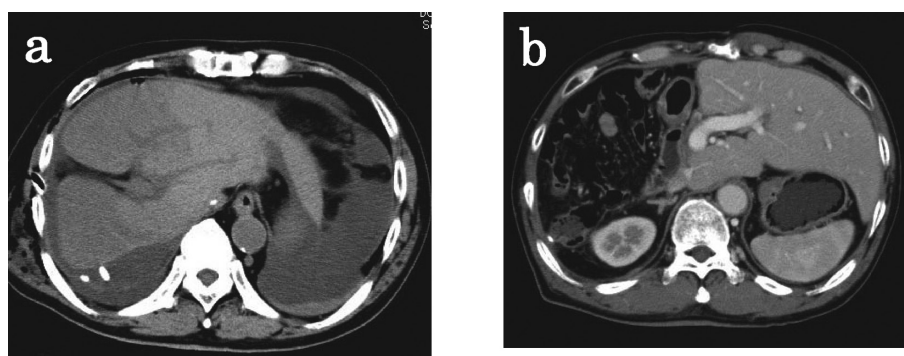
Abdominal computed tomography (CT) before and after fixation of the remnant liver in the anatomical position. The remnant liver has dislocated into the right subphrenic space and is largely swollen. The left side of the remnant liver is shown as a low-density area by plain CT, which possibly represents a congested area of the liver (a). After fixation, the congested area disappeared (b).
